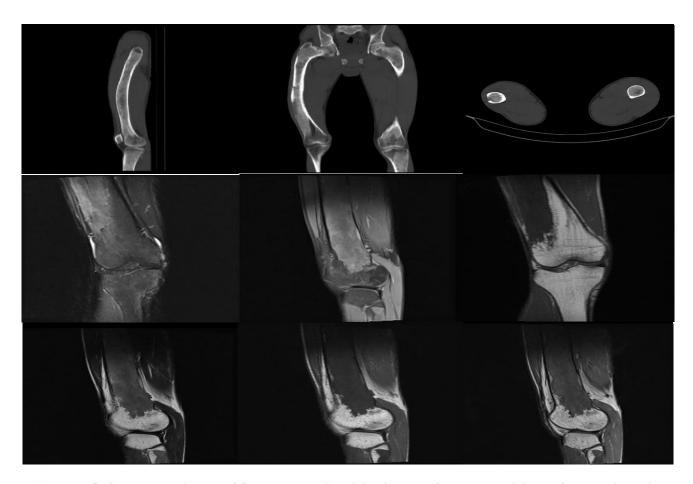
CT and MRI images of fibrous dysplasia arising from the femoral and tibial shaft mostly involving postero-lateral aspect of femur.
